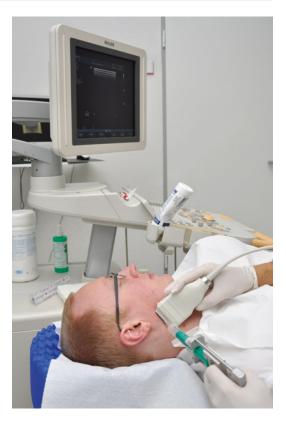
Ultrasonographic examination of parotid tumor of the right side including fine-needle aspiration cytology
